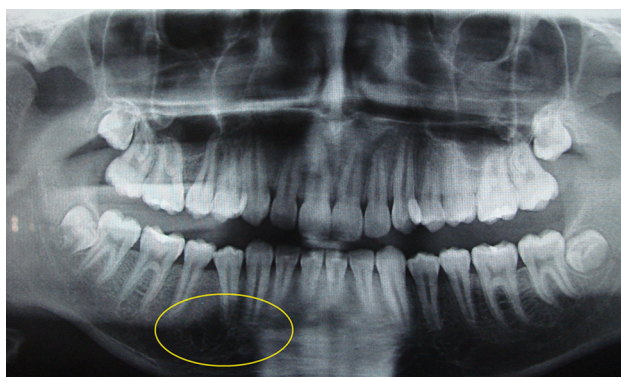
Panoramic radiograph showing bone repair at the lesion site follow-up 24 months.
